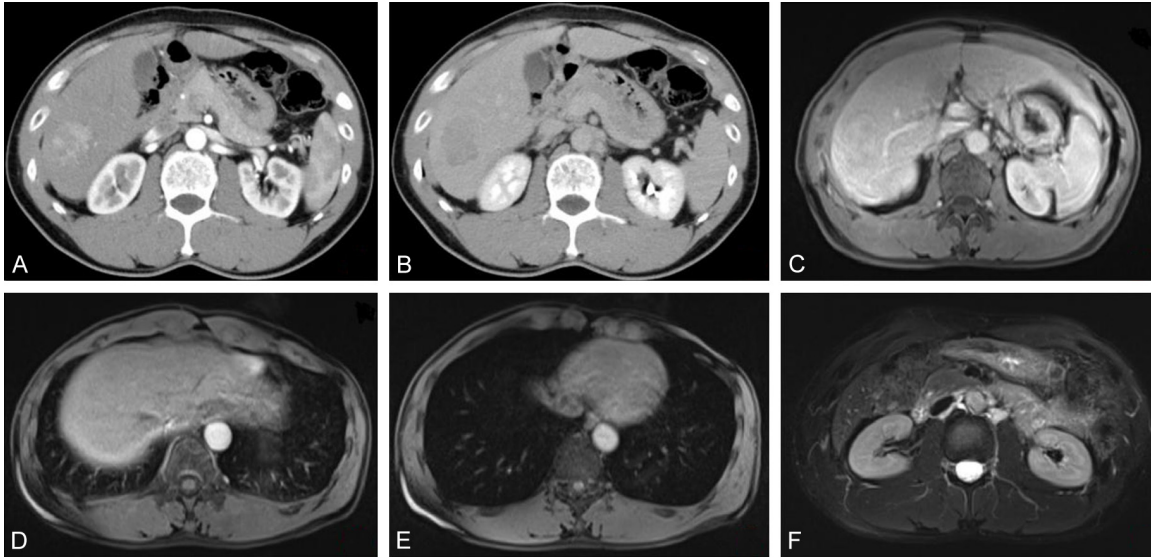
Case image of a 57-year-old male. A: CT-enhanced arterial stage; B: CT-enhanced venous stage; C: EOB-MRI early arterial stage; D: EOB-MRI late arterial stage lesion with mild enhancement; E: EOB-MRI venous stage lesion with mild enhancement; F: EOB-MRI hepatobiliary stage lesion with slightly high signal. EOB-MRI: Gadolinium-ethoxybenzyl-diethylenetriamine pentaacetic acid-enhanced magnetic resonance imaging; CECT: contrast-enhanced computerized tomography.
